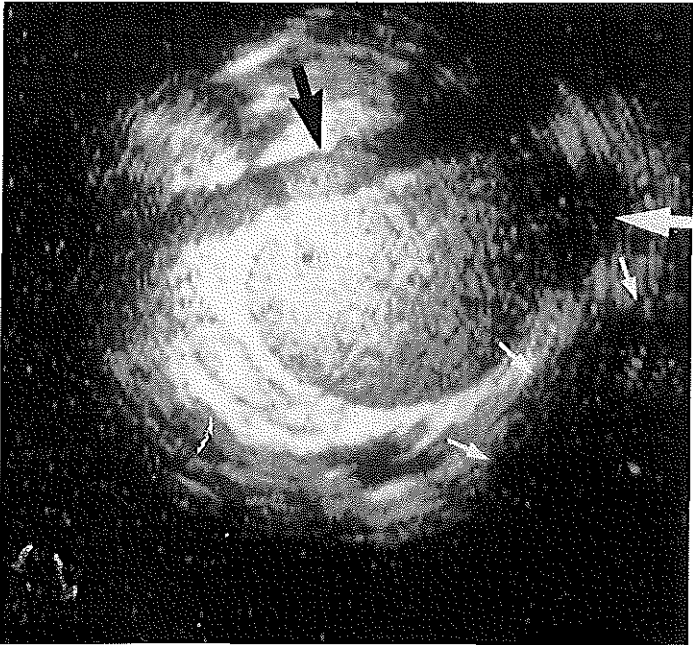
Intravascular ultrasound image (20 MHz) obtained from within the vena cava showing the renal artery crossing over the vena cava and the left renal vein originating from the vena cava. The aorta could not be seen.
